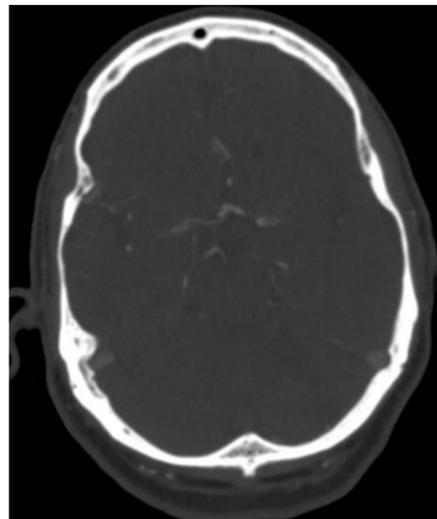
CTA head with occlusion of left MCA at proximal M1
